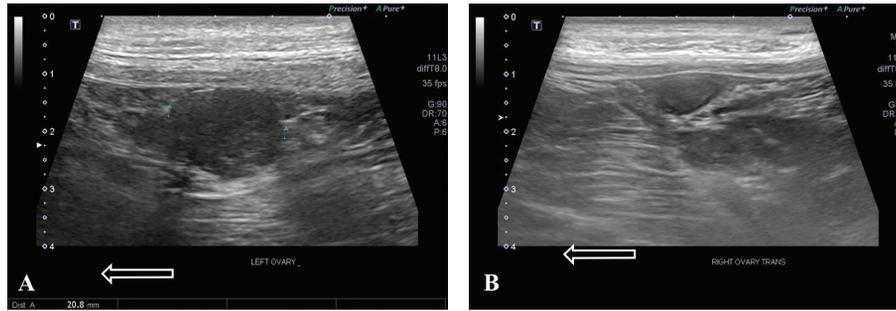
A. Ultrasonographic image of ‘abnormal’ left ovary (note enlarged ovary with a heterogeneously hypoechoic region within the caudal pole) on day 40 of estrus; distance between calipers: 20.8 mm and arrow pointing cranial side. B. Ultrasonographic image of ‘normal’ right ovary on day 40 of estrus and arrow pointing cranial side.
